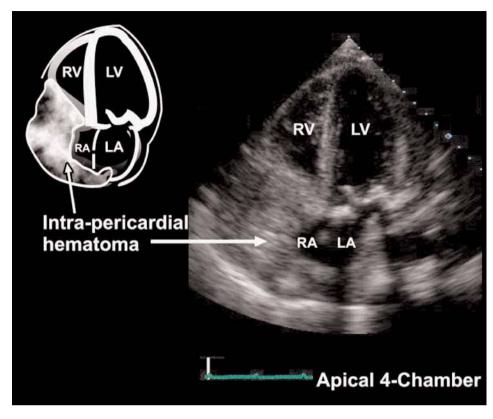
Intra-pericardial hematoma. Apical four-chamber view showing large opacity, apparently within right atrial cavity, which was confirmed to be an intrapericardial hematoma.
